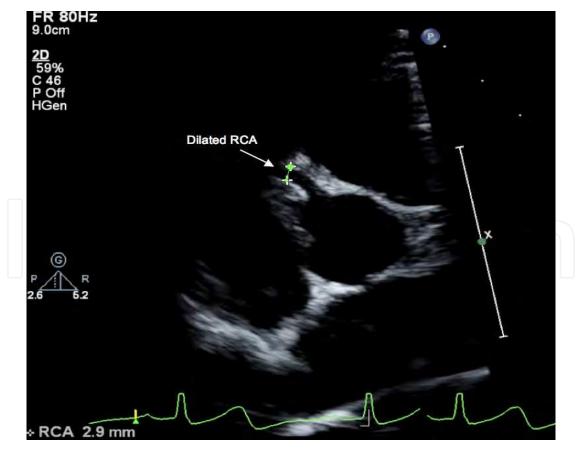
Parasternal short axis echocardiographic image showing a uniformly dilated proximal right coronary artery (RCA).
